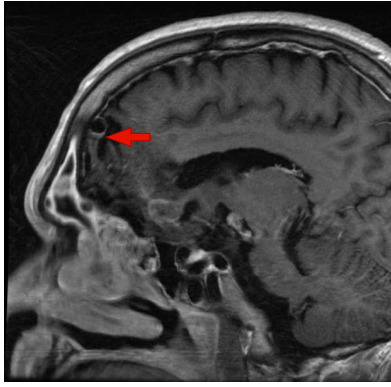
VW-MRI from sagittal view of an AVM draining vein. The red arrow indicates signal enhancement in the vessel wall.
